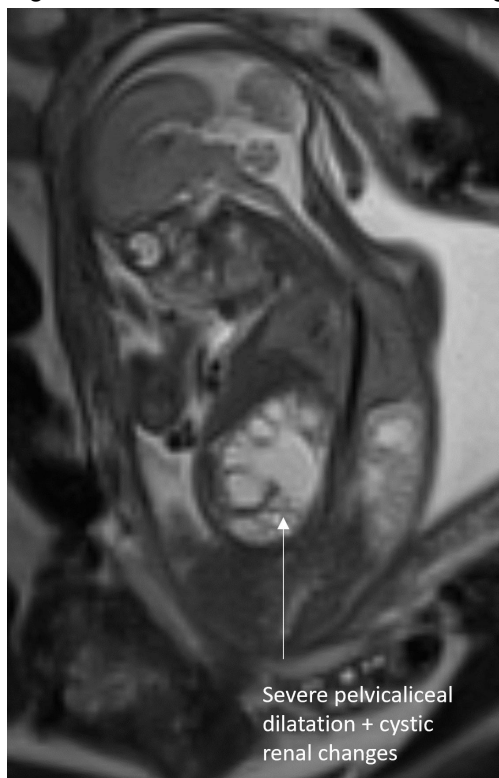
T2 Sagittal MRI image of 23 week fetus with posterior urethral valves
